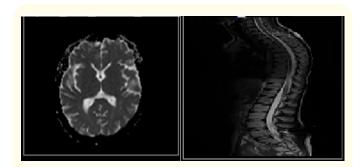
Brain and spinal cord MRI Normal.
